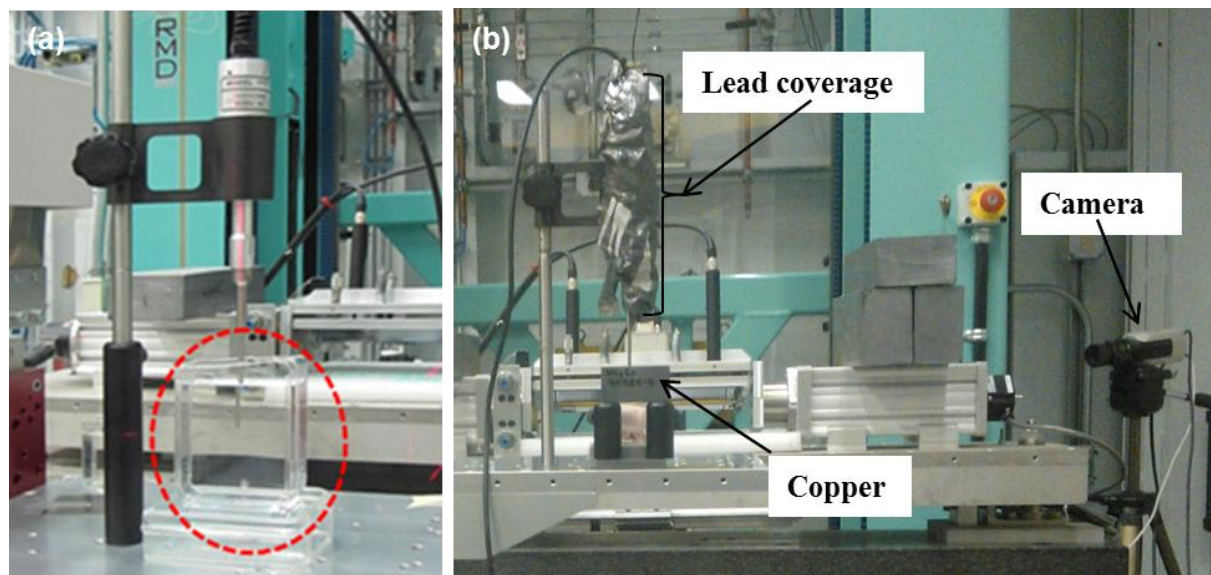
Preparation of the sample for ultrasound treatment and X-ray imaging: (a) mounting the sonicator probe on the scanning stage and inserting sonotrode inside and at the center of sample/water; (b) covering the transducer and sonicator probe with lead shielding and copper and adjusting camera at the sample.
